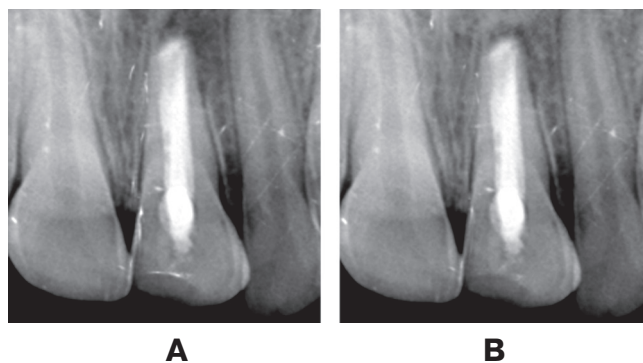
Radiographic image of tooth 21: A – with calcium hydroxide dressing; B – following MTA apexification using a collagen membrane (the red mark indicates 5 mm of MTA putty placed within the canal)
